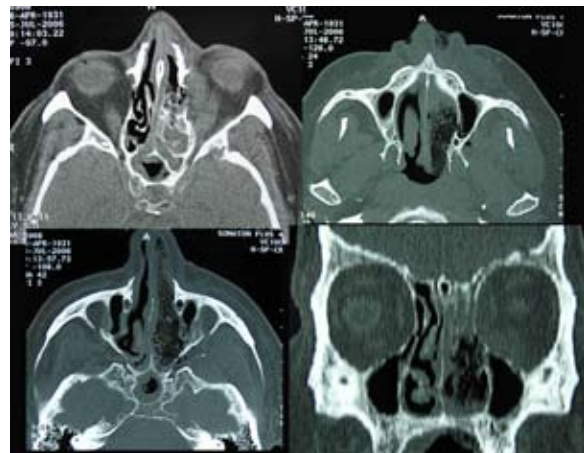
The computed tomography (CT) study showed palatal involvement, left nasal fossa, left maxillary and ethmoid sinus and left orbit occupation
